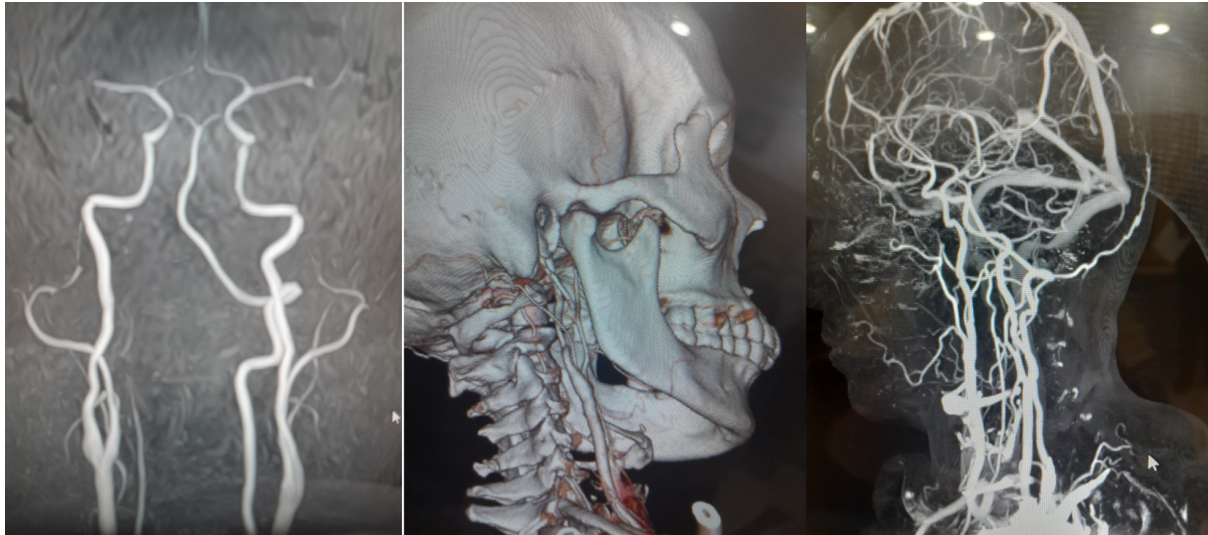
Follow up Magnetic Resonant Angiogram (MRA) and CT Angiogram brain after 3 months showing complete restoration of dissected lumen of right internal carotid artery.
